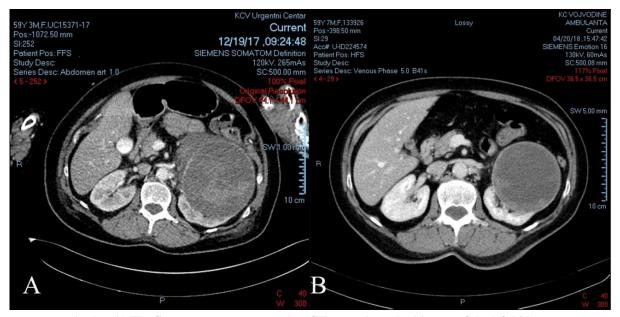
A) The first computer tomography (CT) scan showed a big cyst of the left kidney; B) Control CT with the same kidney cyst.
